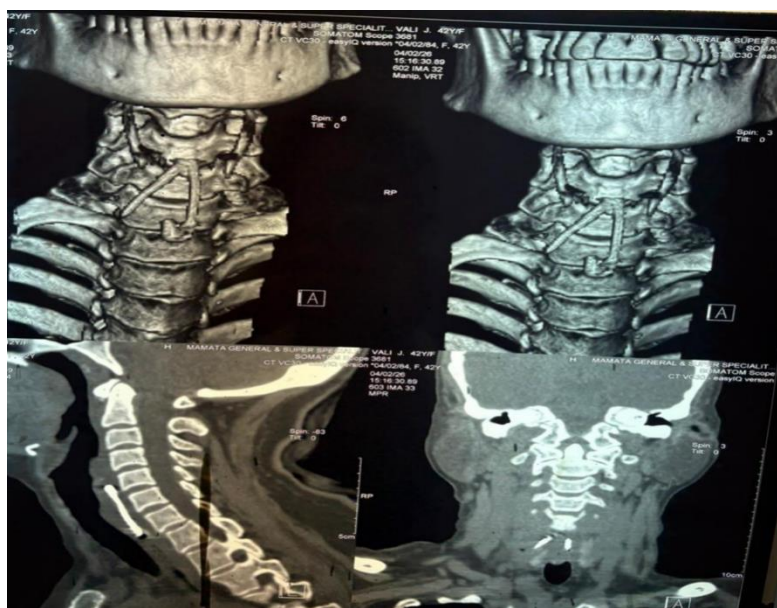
CT neck with 3D reconstruction, sagittal, and coronal views demonstrating an open metallic safety pin impacted at the C5–C6 level in the postcricoid region.
